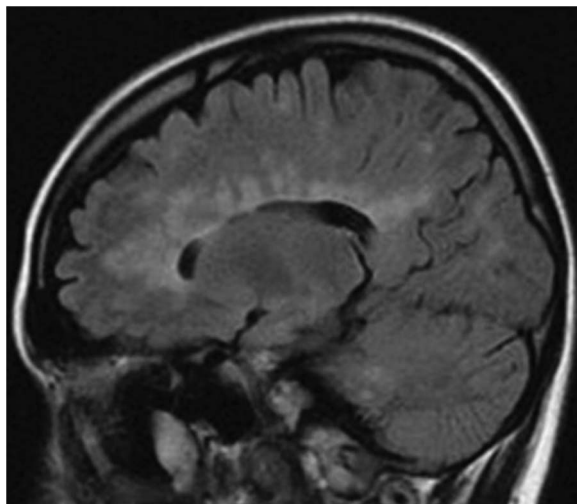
Brain MRI of a girl with relapsing-remitting multiple sclerosis performed when she was 15 and a half years old. Her parasagittal FLAIR image (TR 8002, TE 155) shows multiple hyperintense signal abnormalities within the pericallosal white matter (Dawson fingers), subcortical cerebral white matter, and brachium pontis.
